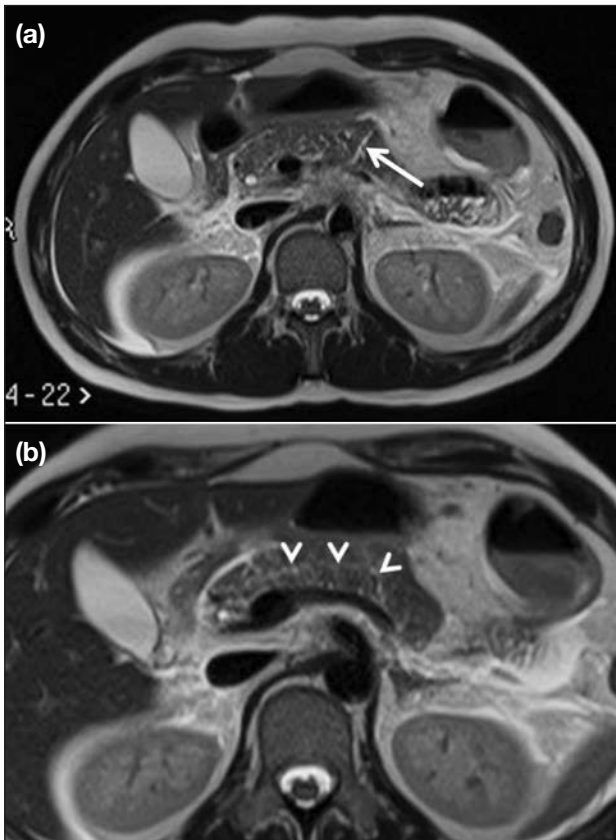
(a) Axial T2-weighted magnetic resonance imaging 2 days after initial presentation confirms the presence of pancreatic transection involving the pancreatic body (white arrow). (b) Axial T2-weighted magnetic resonance imaging 2 days after initial presentation shows the intact main pancreatic duct lying just cephalad to the pancreatic transection (white arrowheads).
